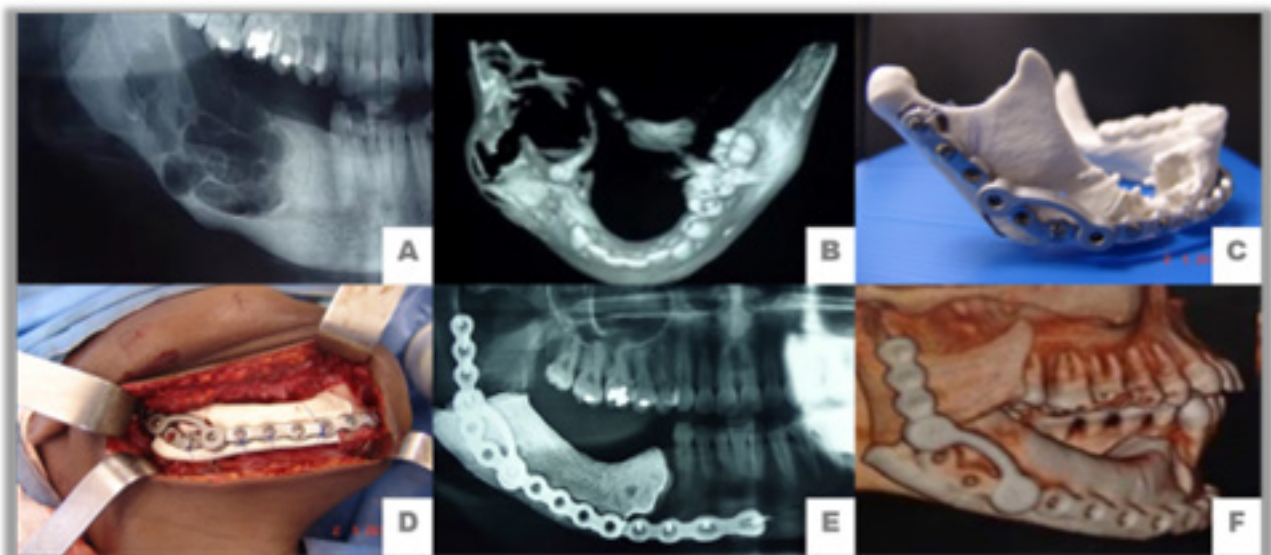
Panoramic radiography (A) and 3D computerized tomography with reconstruction (B) showing the loss of continuity of the mandibular bone structure. In the preoperative phase, prior adaptation of the reconstruction plate with angular reinforcement was performed using prototyping (C). During the intraoperative period, the 2.4 macroplate with angular reinforcement and surgical cement was observed (D). Panoramic X-ray (E) and 3D computerized tomography with reconstruction of the immediate postoperative period (F).
